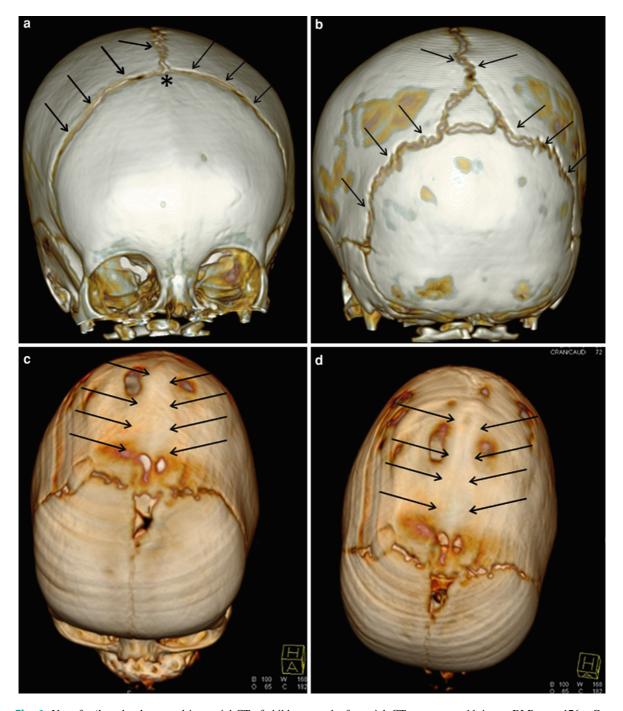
Use of a 'low-dose' protocol in cranial CT of children for exclusion of craniosynostosis: Because the primary goal of the CT study is visualization of the skull bone and sutures, lower kV setting at 100 kV or 80 is possible. a-b :A 6-monthold girl with clinically small fontanel: Volume rendered, anterior (a) and posterior (b) CT view of the skull shows absence of anterior fontanel (*asterisk*), but normal cranial sutures (*arrows*) and no evidence for craniosynostosis. CTDI vol of cranial CT exam was 11.4 mm–DLP was 176 mGy, which corresponds with a calculated effective dose of 1.9 mSv c-d:A 3-month-old boy with clinical suspicion of craniosynostosis: volume rendered anterior (c) and superior (d) view confirms the presence of craniosynostosis with a premature closure and bony fusion of the sagittal suture (*arrows*). CTDI vol of cranial CT exam was 11.5 mm–DLP was 181 mGy, which corresponds with a calculated effective dose of 1.98 mSv
